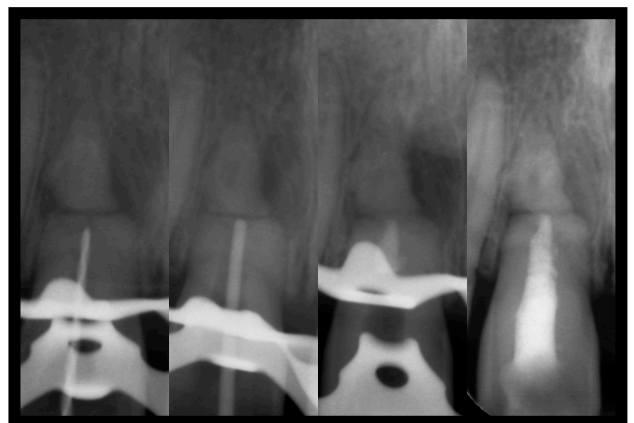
Treatment radiographs, from left: Working length; masterpoint; MTA placement; Posttreatment result, 11. Nov 2010
